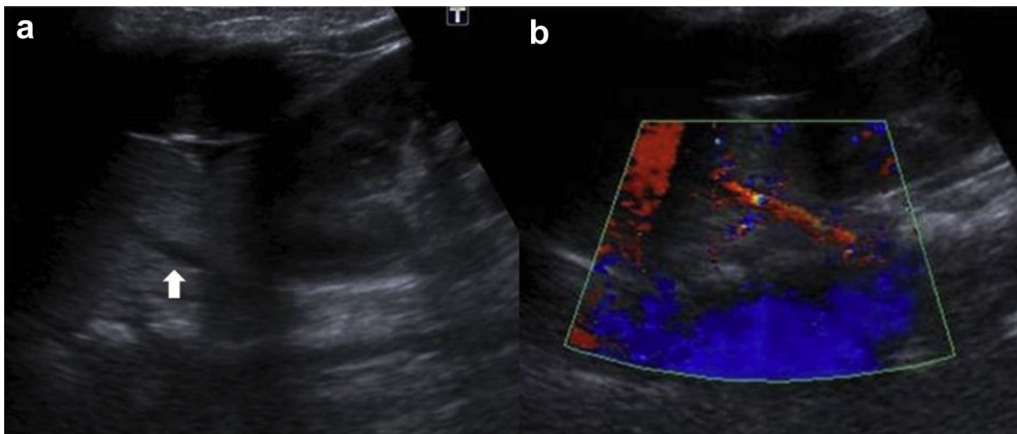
B-mode (a) and color Doppler sonography (b) demonstrates the mass is located cranial to the left kidney and has a feeding artery (arrow).
